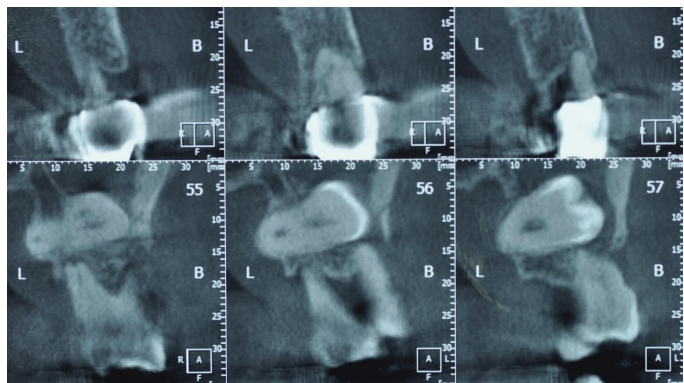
From the CBCT, a hypodense and well-circumscribed lesion surrounds the crown of the third molar.
